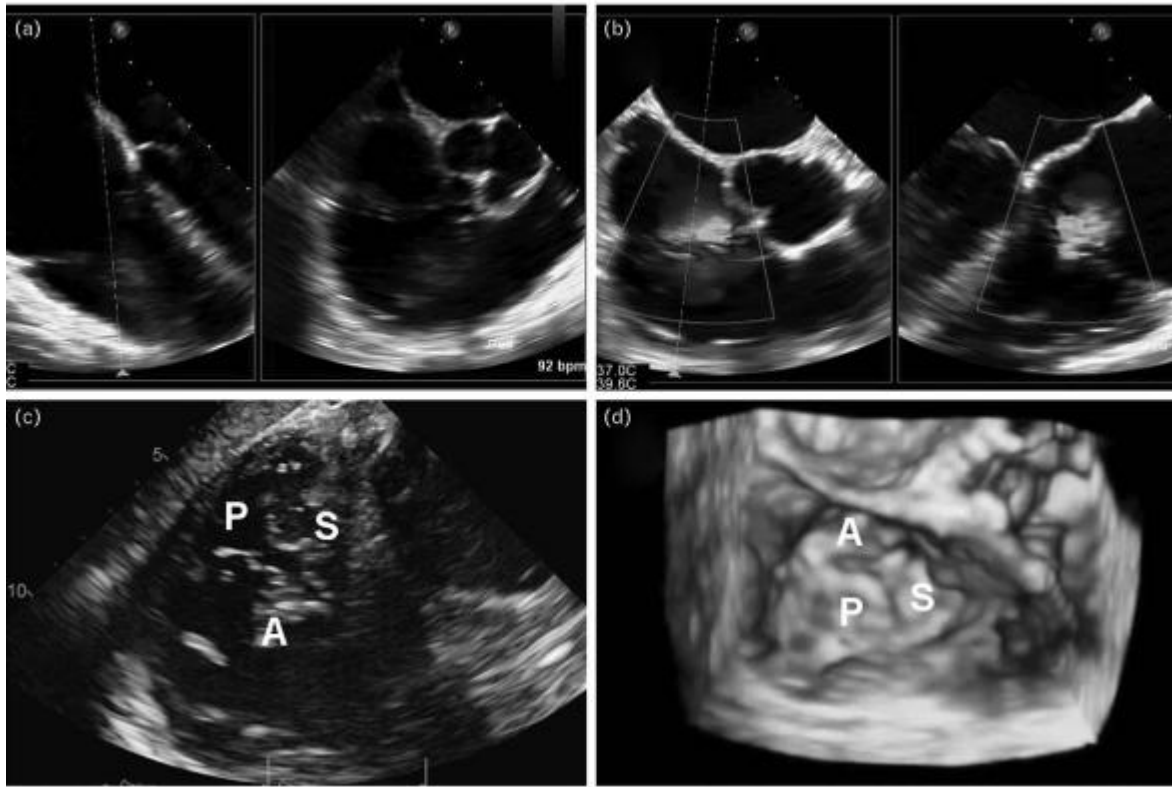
Echocardiographic views of the tricuspid valve for transcatheter tricuspid valve intervention screening. (a) Midesophageal biplane views (left panel: 08 view, right panel: 608 view) of the tricuspid leaflets and annular dimensions. (b) Color Doppler imaging using biplane imaging of the tricuspid valve. Leaflet pairs can be more accurately imaged and assessed using three-dimensional biplane imaging based off of a 60–90° imaging plane of the tricuspid valve. (c) Deep transgastric view of the tricuspid valve (left panel: 1008 right ventricular long axis view, right panel: 108 en-face tricuspidvalve view). (d) Three-dimensional volumes are often clearest from the lower esophageal window and can be manipulated to display an en-face surgical view, or reconstructed using multiplane reconstruction for specific imaging planes. (quoted from Ho, et al., 2019)
